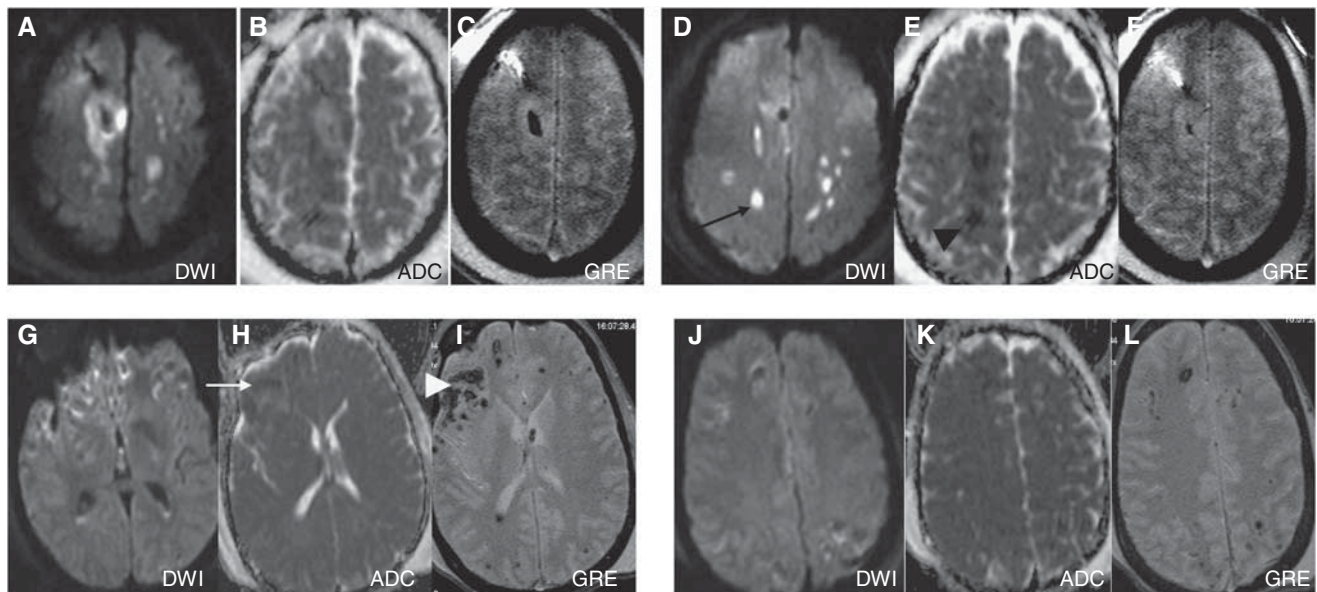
Example of structural lesion characterization: Two different patients are shown (A–F) and (G–L). Two separate axial slices per subject are shown with three image sequences per axial slice consisting of the DTI (left), DTA-ADC (middle), and GRE (right) in each sequence (panels A–F). The top row shows that the single patient had evidence of DTI-ADC hypointense (black arrowhead) and diffusion-weighted hyperintense lesions (black arrow) in the absence of obvious hemorrhage (panels C, F). The bottom row (E–H) shows an example of a patient with diffuse hemorrhagic lesions (white arrowhead) that colocalize with ADC (white arrow) and DWI areas. In 31 of 32 patients, DTI diffusion lesions were uniformly colocalized with GRE lesions as in panels G–L.
